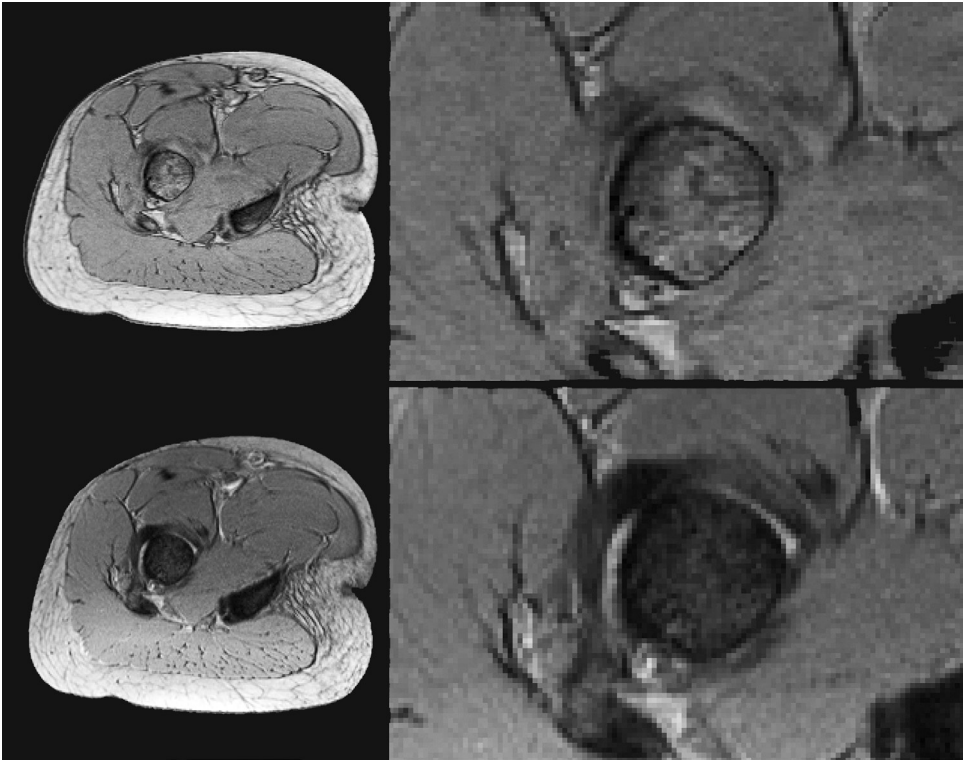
MRI images of a femoral neck. The imaging plane has been set perpendicular to the axis of the femoral neck. A FLASH image is shown in the first row on the left, with a magnified image of the region of interest shown at right. A MEDIC image is shown in a similar way below.
